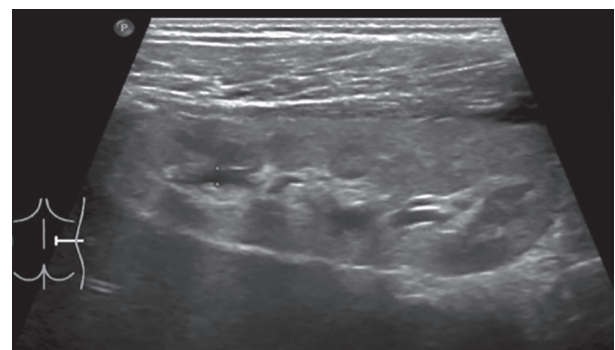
Ultrasound of the right kidney in the presented patient at the age of seven
